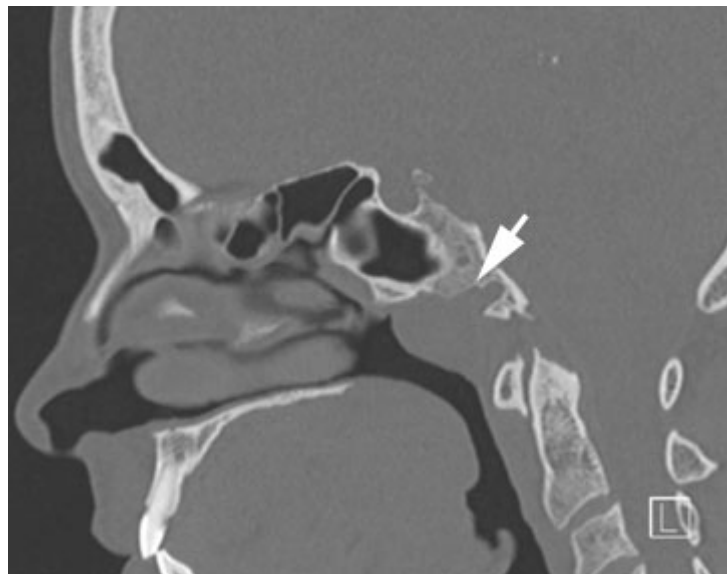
Sagittal bone-windowed CT without contrast demonstrating a soft tissue mass in nasopharynx. White arrow: median basal canal in clivus.
